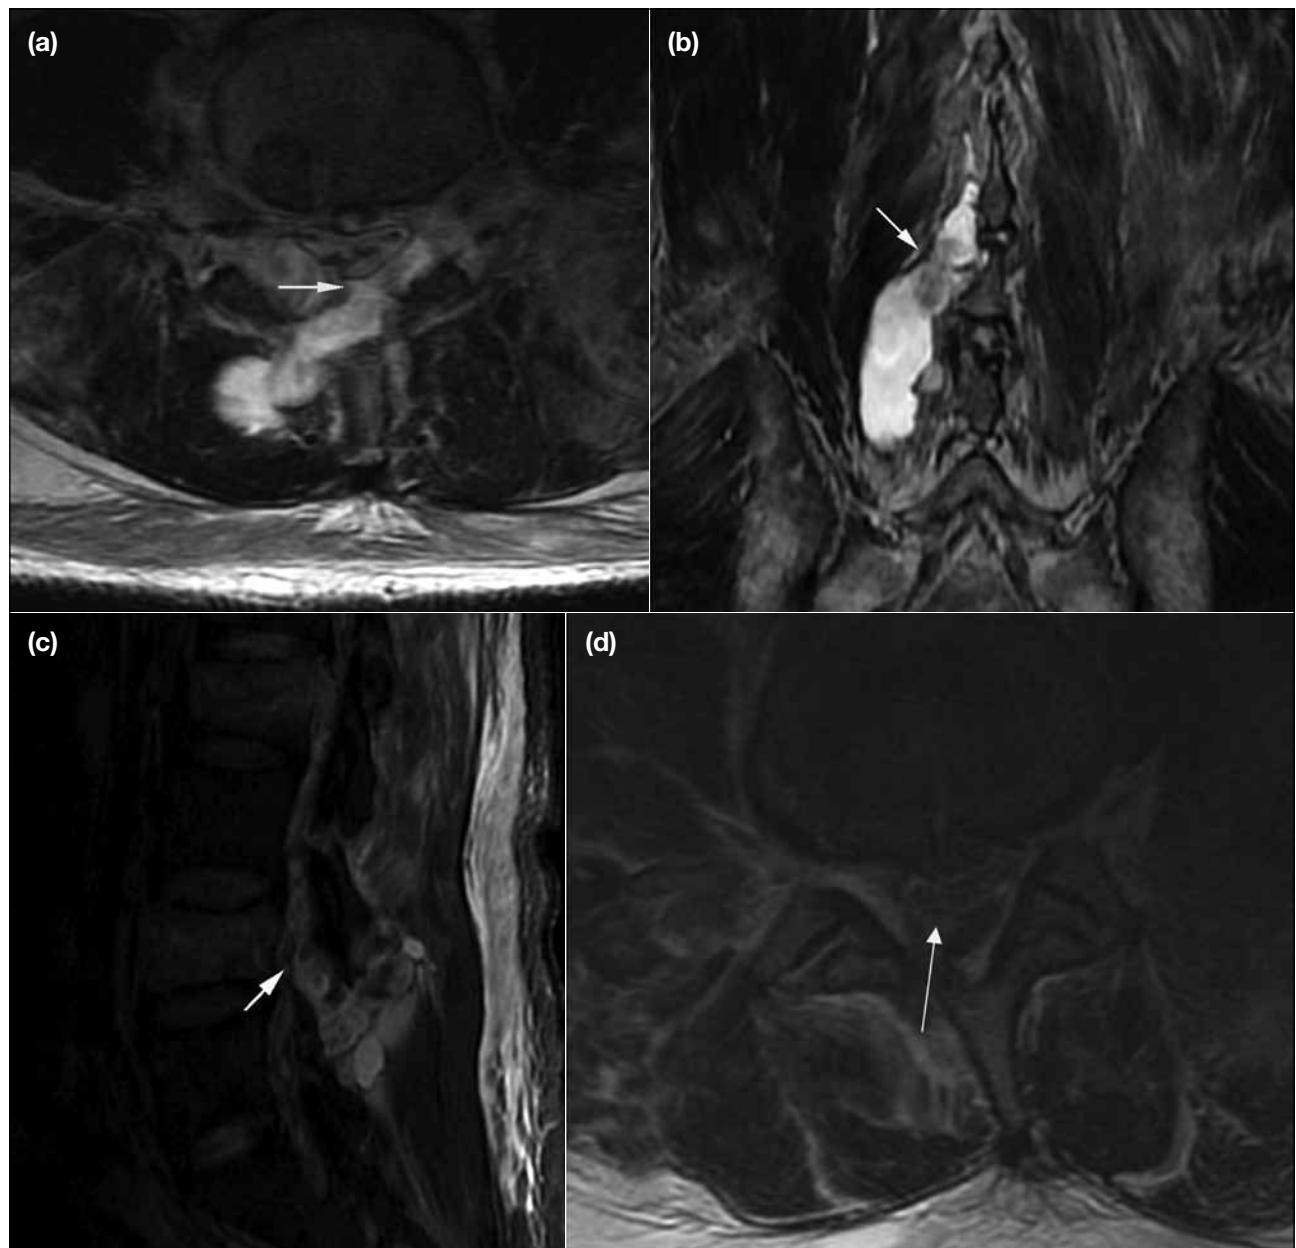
Follow-up magnetic resonance (MR) after a week. (a) An axial T2-weighted image at the level of the L4 lamina clearly show a dural defect and pseudomeningocele (arrow). (b, c) Coronal T2-weighted and sagittal inversion recovery images from follow-up MR show right-sided pseudomeningocele tracking inferiorly (arrow). (d) An initial axial T2-weighted MR image at the level of the L4 lamina shows irregularity of the thecal sac outline (arrow), indicating the site of dural injury (not recognised at the time).
